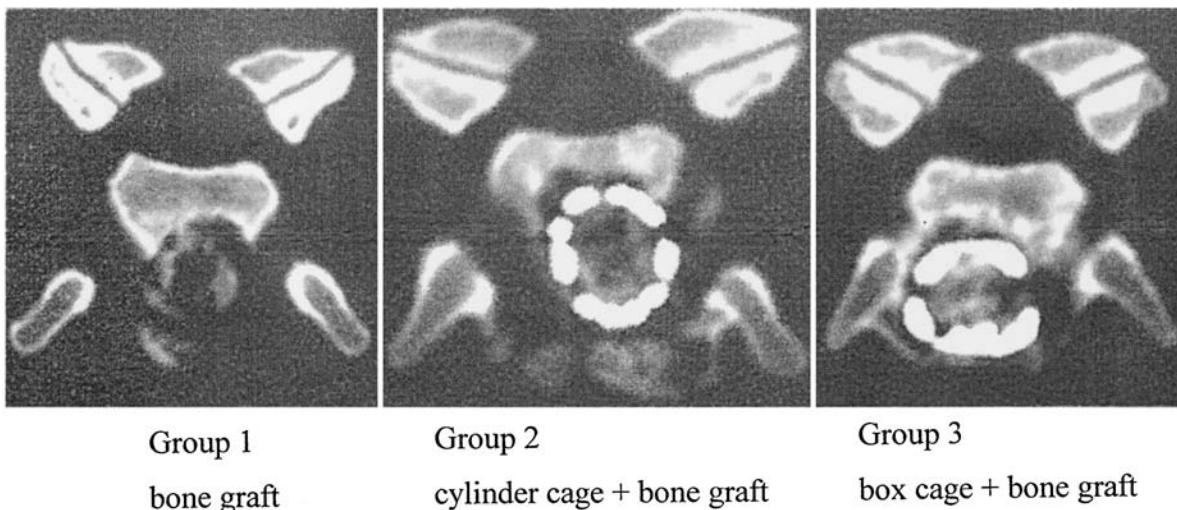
Computerized tomography analysis. After 12 weeks, interbody fusion was evaluated on axial CT scans obtained parallel to the intervertebral space.
